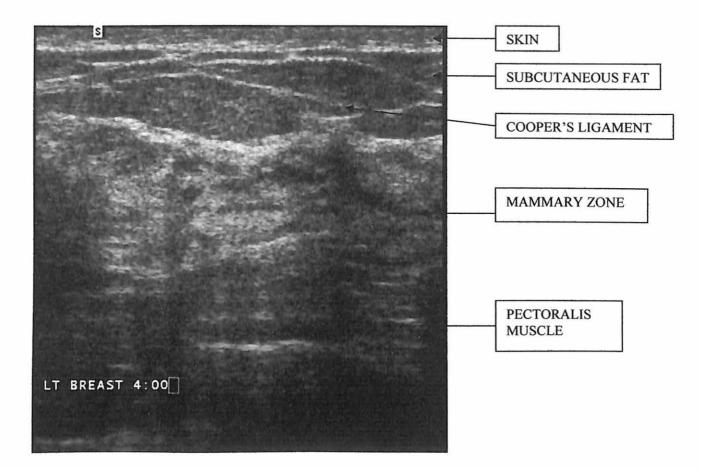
Normal sonographic anatomy of the breast.
